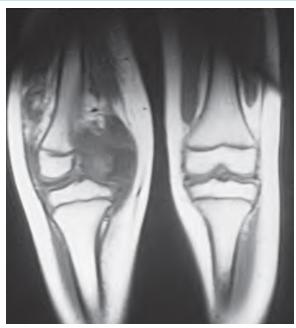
Lomentospora (formerly Scedosporium) prolificans septic arthritis of the knee in an otherwise healthy 12-year-old boy. This condition developed in association with a splinter obtained during a playground fall. Magnetic resonance imaging depicts osteomyelitis of the medial condyle.
